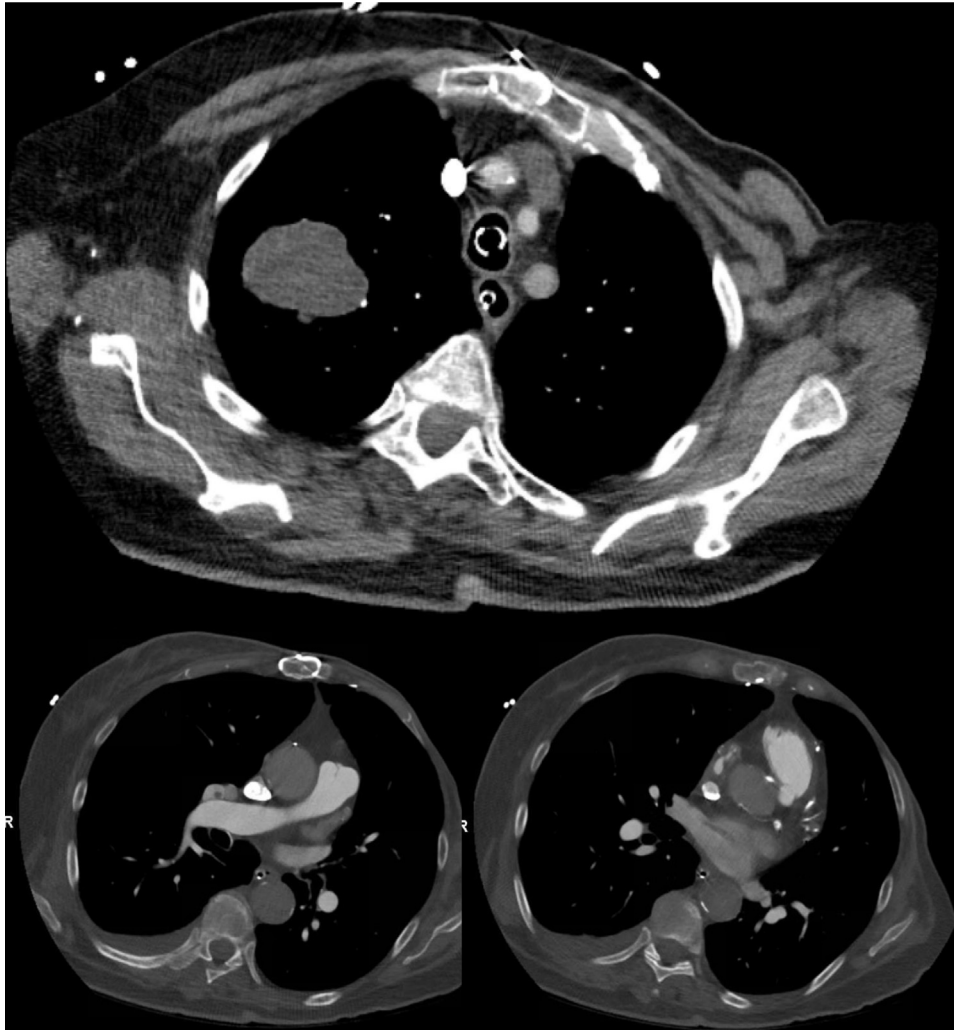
Computed tomography scan of the chest characterizing the right upper lobe mass and extension of the mass into the pulmonary veins.
